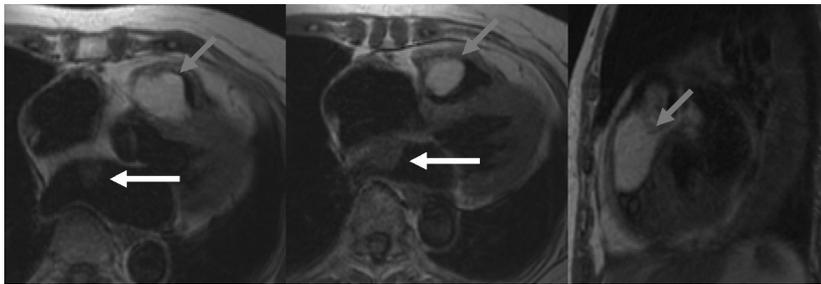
Axial (a,b) and sagittal (c) T1-weighted spin echo images precontrast. The larger mass (dark arrow) causes incomplete obstruction of the RVOT. Note how the smaller mass (light arrow) appears attached to the inter-atrial septum.
